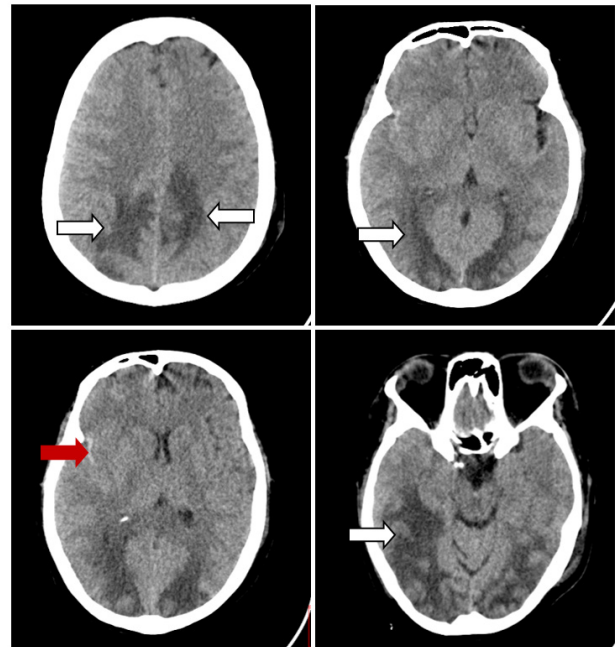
CT scan of the head showing hypodense areas in bilateral parietotemporooccipital as well as frontal regions. (White arrows) A small hyperdensity in the right Sylvian fissure which may be minimal subarachnoid hemorrhage. (Red arrow)
